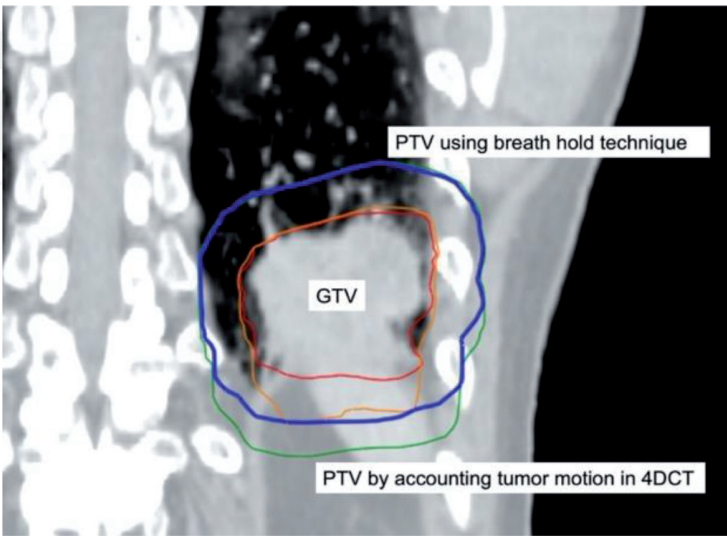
Breath hold technique can minimize a target volume. Non-small cell lung cancer in the lower lobe of the left lung. Red, orange blue, and green indicate gross tumor volume (GTV), accumulated GTV on four-dimensional computed tomography (4DCT), planning target volume (PTV) using the breath-hold technique (exhale), and PTV, which was generated by accounting tumor motion in 4DCT, respectively. The breath-hold technique reduces the target volume.
